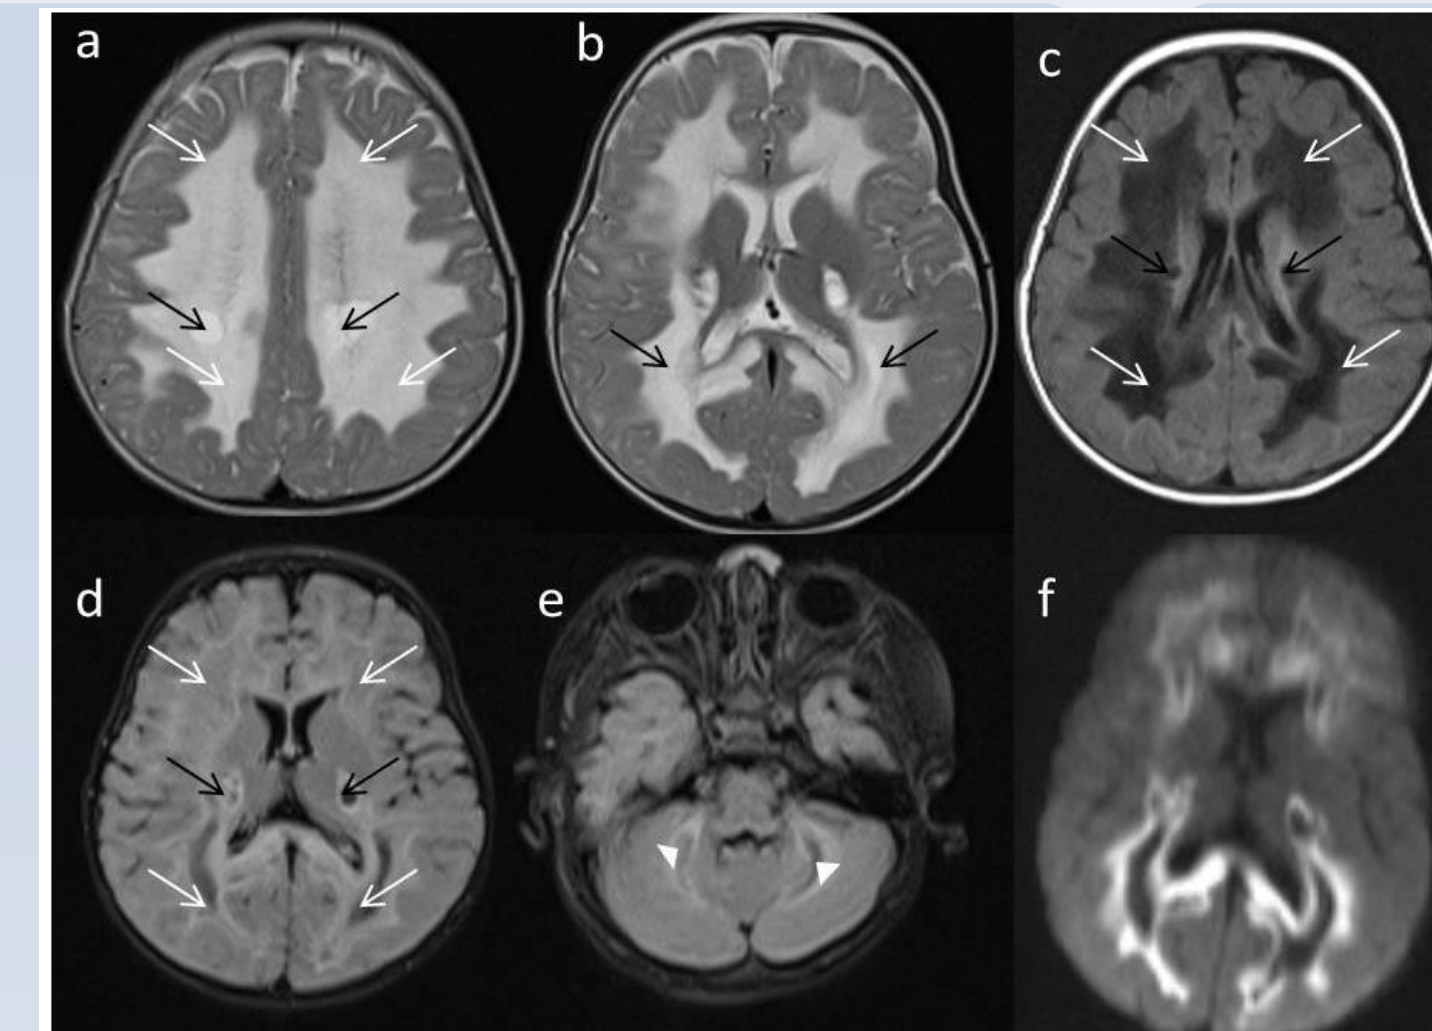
Axial T2w (a, b) diffuse hyperintensities in bilateral cerebral hemispheres (white arrows), (c) hypointense on T1 (d) mildly hyperintense on FLAIR images. Multiple cystic changes in periventricular WM, basal ganglia and corpus callosum (black arrows) and bilateral cerebellar hemispheres (e). DWI (f) shows diffusion restriction with sparing in cystic areas
